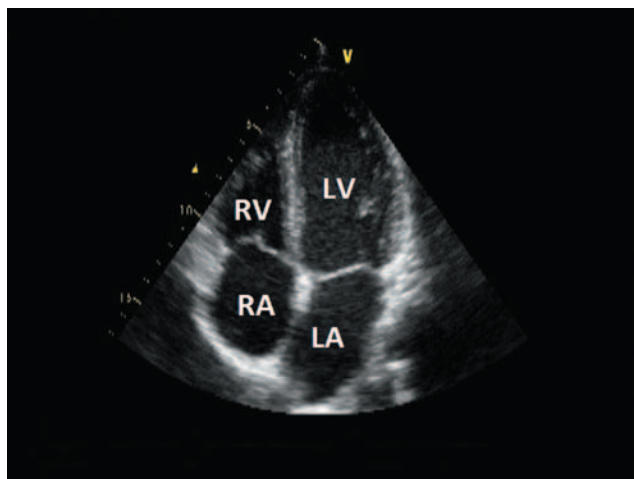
Normal apical 4-chamber picture obtained at position 2. RA = right atrium; RV = right ventricle; LA = left atrium; LV = left ventricle.
